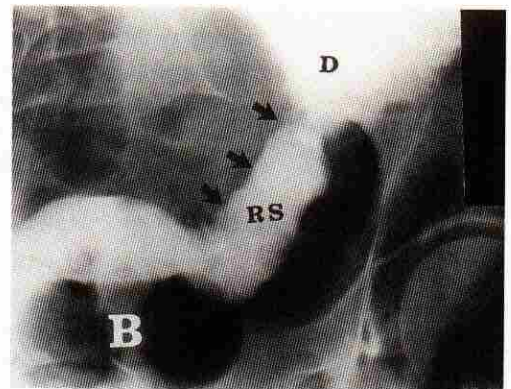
Spot radiograph shows uniform narrowing of the sigmoid colon (arrows). Biopsy showed aganglionosis consistent with adult Hirschsprung's disease. (B = rectal balloon catheter; RS = sigmoid colon; D = descending colon)
